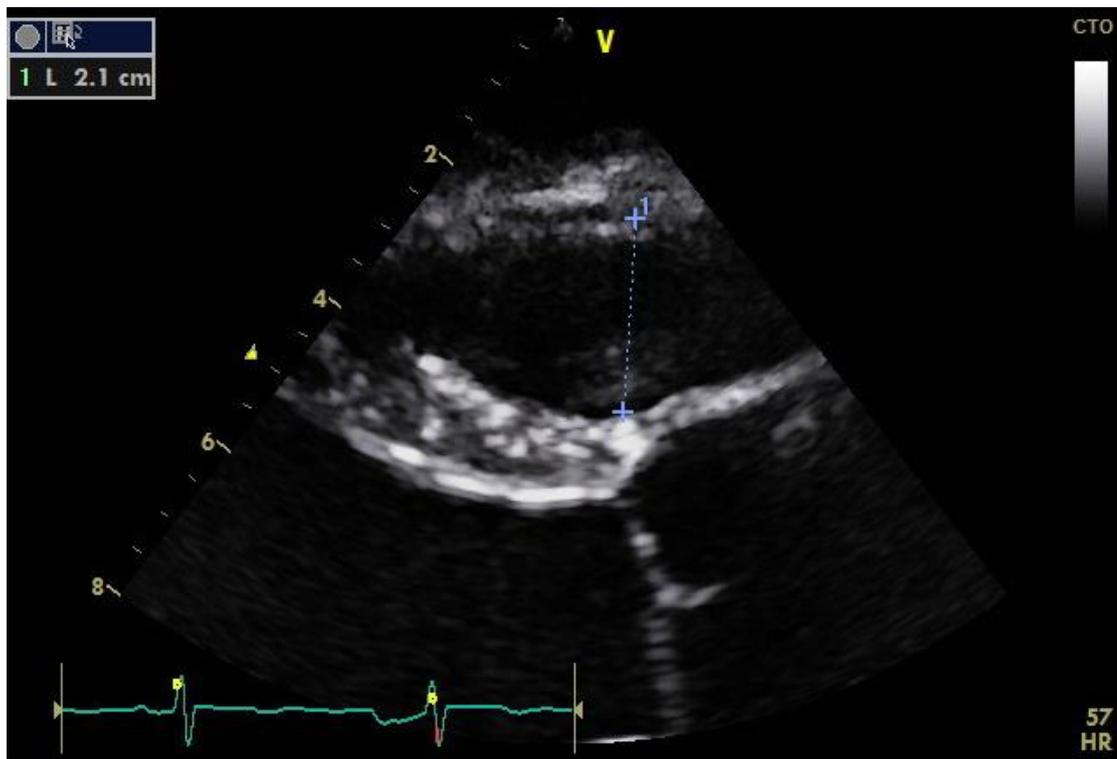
1: RV outflow tract diameter at the parasternal long-axis view (RVOT-PLAX)
